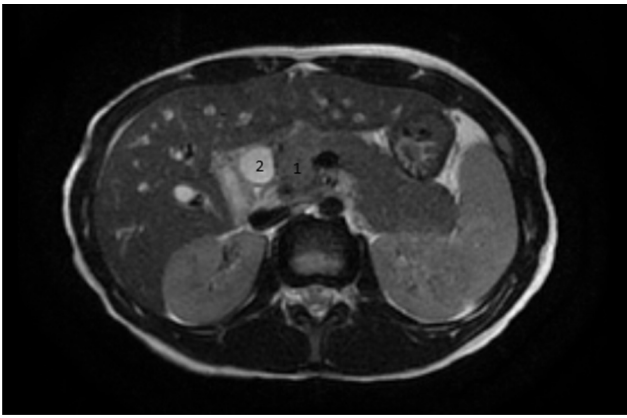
T2-weighted magnetic resonance imaging (MRI) demonstrating a mass in head of pancreas (1) causing massive dilatation of the common bile duct (2).
